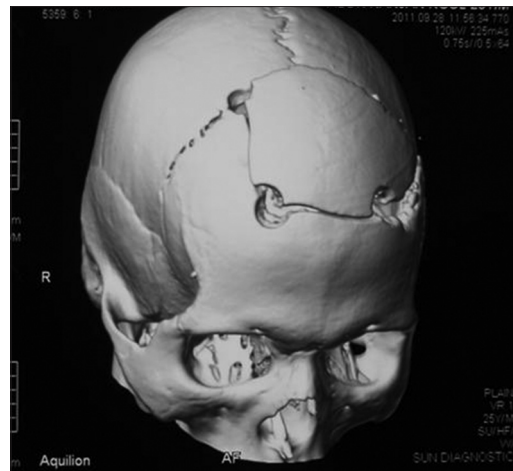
Computed tomography scan picture showing vertex epidural hemorrhage (b) with coronal suture diastases (a)
